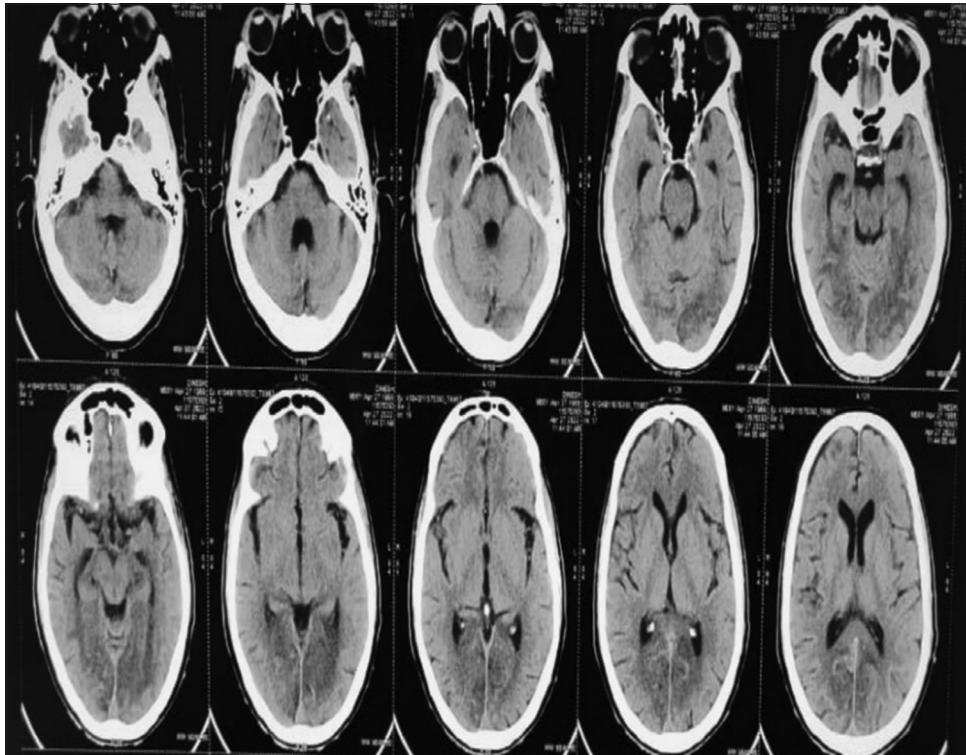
Computed tomography head was done on post-op day 8th which was suggestive of occipital hypo densities
